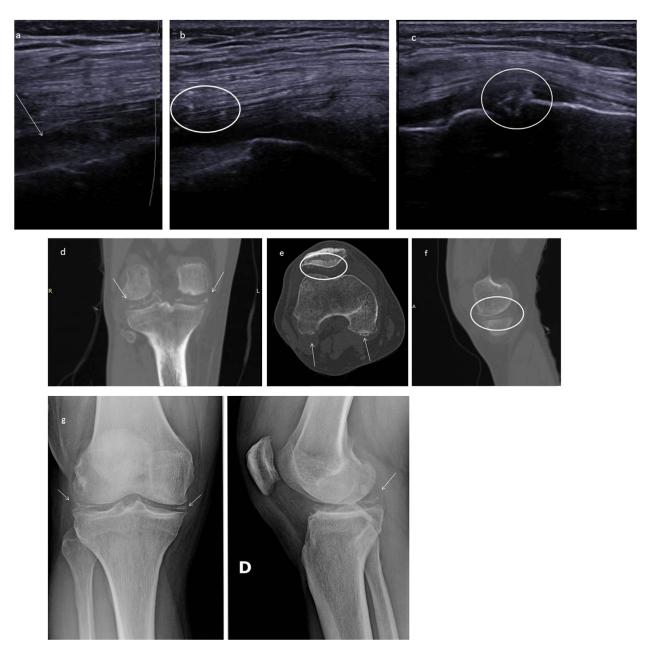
US exam. (a) Synovial hypertrophy (arrow), (b) point hypergenic deposits in the synovium (circle) and (c) hypergenic linear deposits in the meniscus (circle) CT exam. (d) Coronal plane hyperdense lineal deposits in fibrous meniscus (arrow), (e) axial plane hyperdense pinpoint deposits in hyaline cartilage (arrow and circle) and (f) sagittal plane hyperdense linear deposits in meniscus (circle). (g) RX exam AP-LL. (f) Linear deposits in the fibrous meniscus (arrow).
